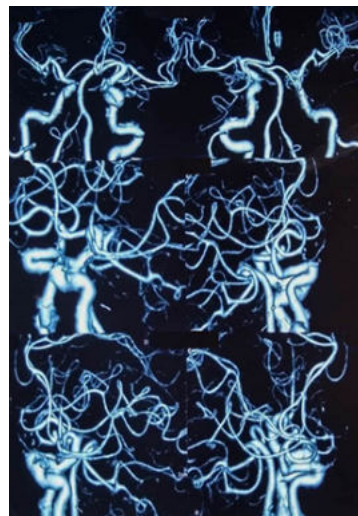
Computed tomography cerebral angiogram showing saccular aneurysm of 3.1 x 2.7mm arising from anterior communicating artery
